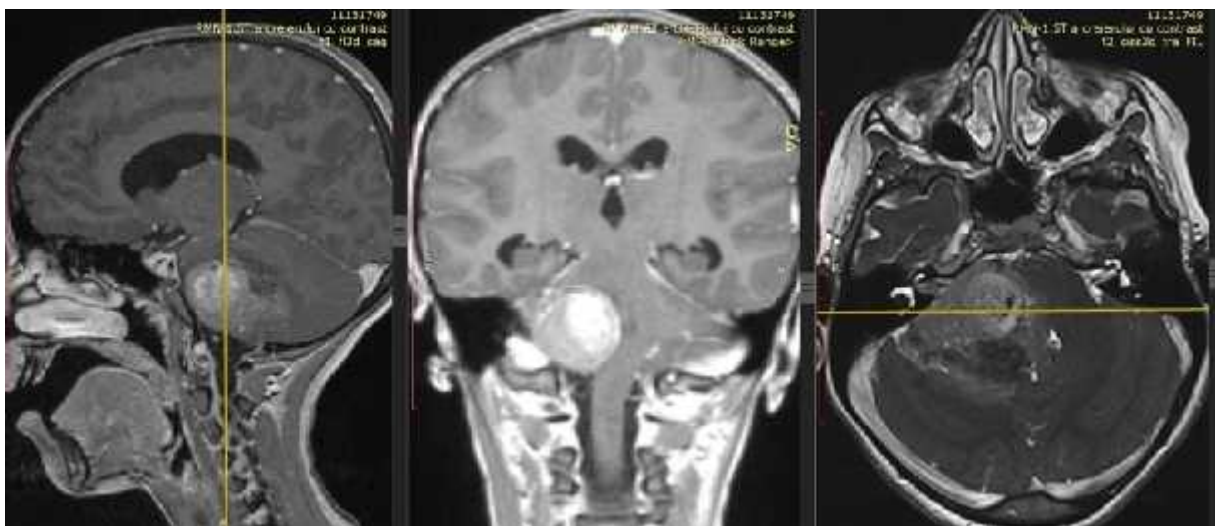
Patient L., 9 years. Preoperative MRI: UPC tumor
